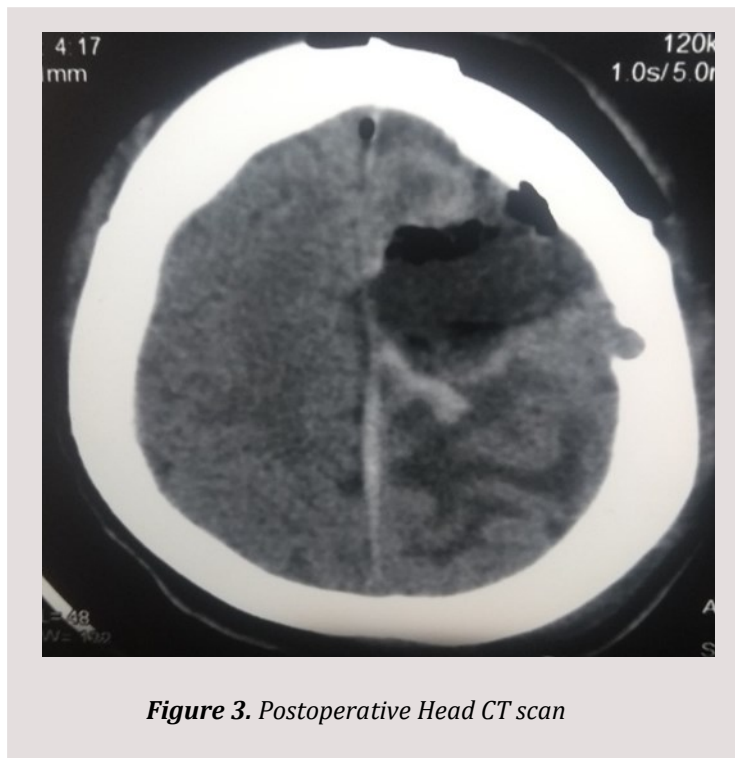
Postoperative Head CT scan
